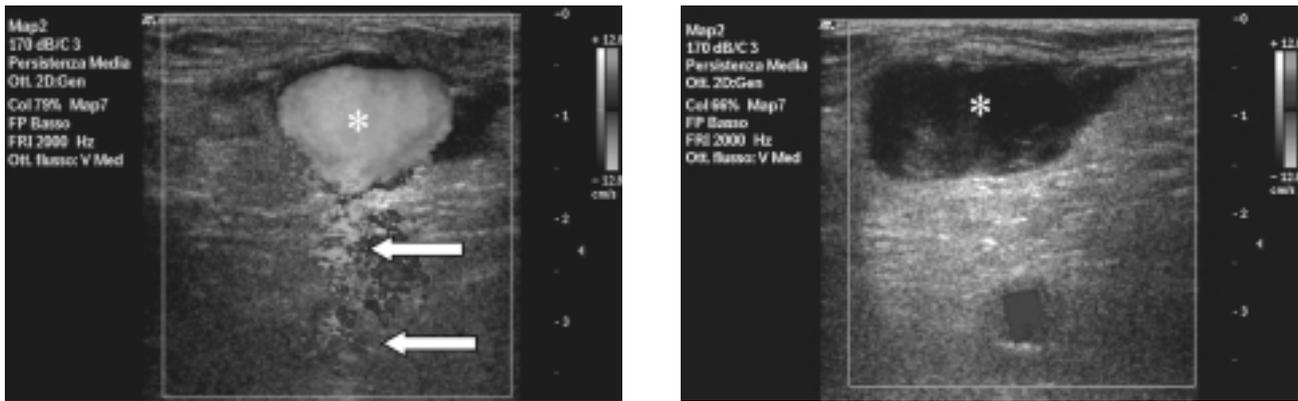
Left panel: color duplex ultrasound view of the pulsating hematoma (*), its neck (arrow) and the relationship with the femoral artery (arrow). Right panel: complete obliteration of the cavity (*).
